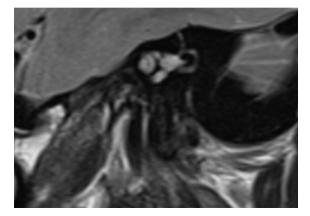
The T2-weighted MRI oblique sagittal image of left temporal bone. CSF delineates the four nerves of the IAC. Cochlear nerve inferiorly to facial nerve was absent.
